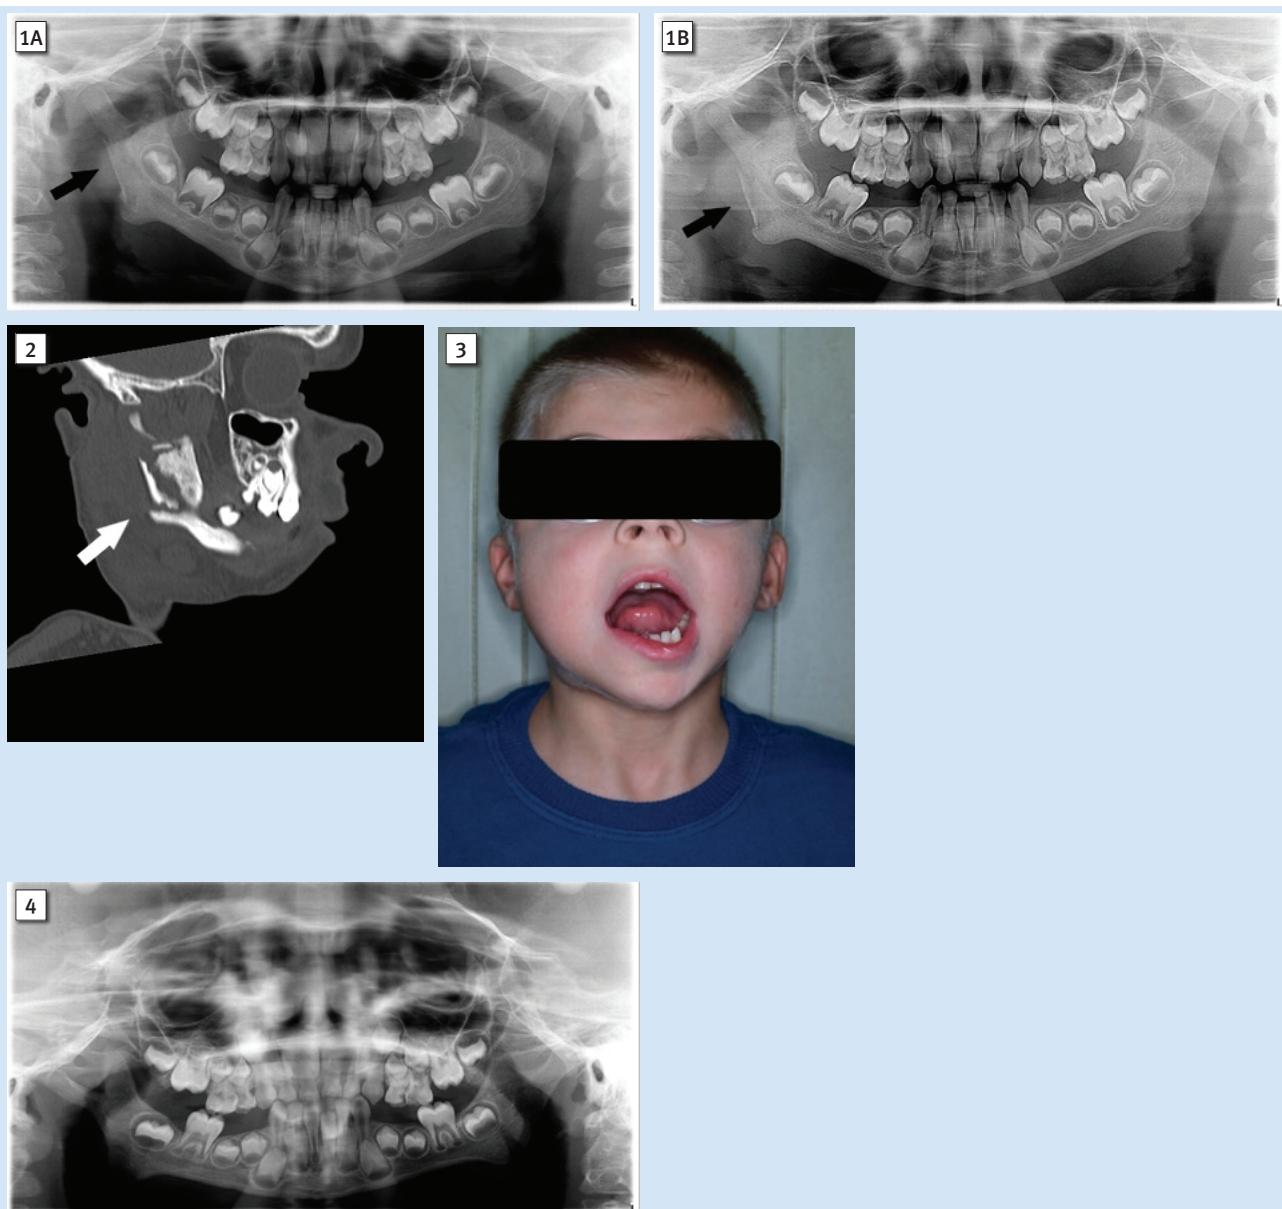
A Dental panoramic radiograph showing the discontinuity of the right mandibular ramus (black arrow).
